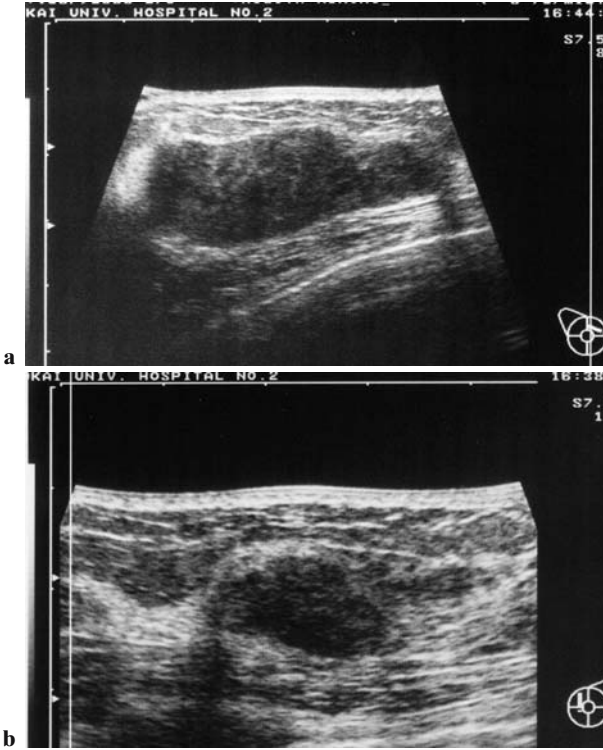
Ultrasonogram of the right (a) and left (b) side of breast with M1 of the FAB subtype after 8 months of bone marrow transplantation. There were bilaterally hypo-echoic solid masses with slight internal echogenicity. The posterior echo enhancement is demonstrated
